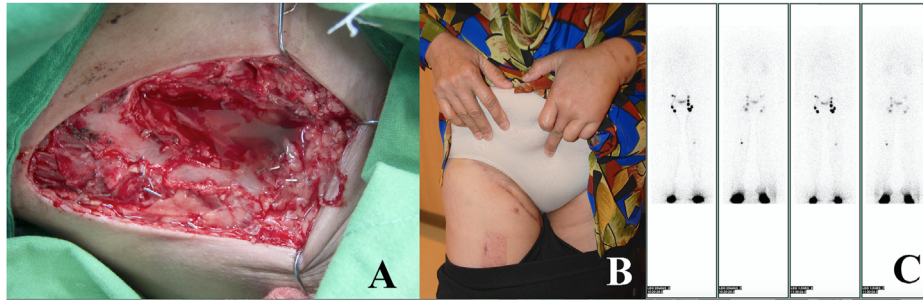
Patient with left upper extremity lymphedema who underwent vascularized right groin lymph node transfer. (A) Picture shows lymph leakage after flap harvest. Clip and ligation was performed. JP drain was placed and maintained for 6 days. (B) Picture shows at 24 months of follow-up no donor site morbidity from donor site. (C) Postoperative lymphoscintigraphy confirmed no iatrogenic lymphedema over the donor site at 24 months of follow-up.
